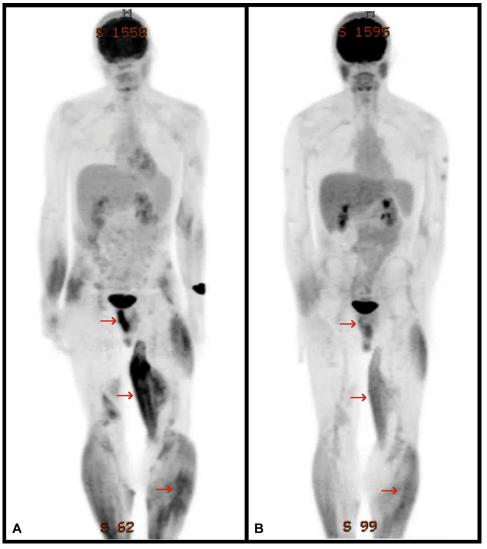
Whole-body PET/CT scans (A) before high-dose prednisone regimen (June 2016) and (B) after high-dose prednisone regimen (July 2016). Red arrows denote areas of particular interest.
